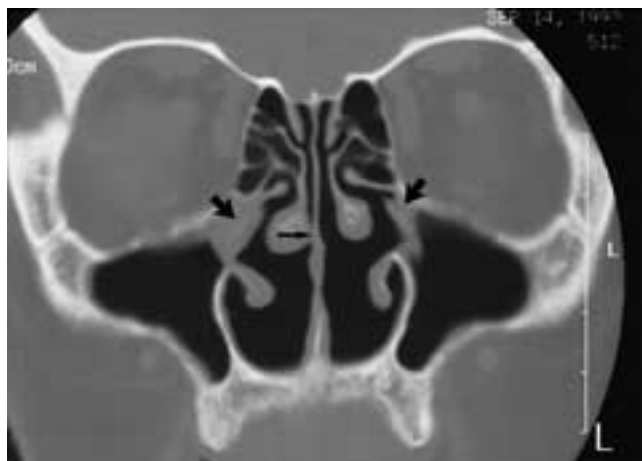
Recurrent symptoms, probably due to functional and flow changes after extensive FESS. Postoperative findings on this sinus coronal CT scan include a septoplasty, resection of most of the inferior turbinates, and a medialized right middle turbinate (black arrows). There is soft tissue in both maxillary sinus ostia (thick arrows). The soft tissue on the right is polypoid and probably represents recurrent polyps. On the left, it likely represents scar.
